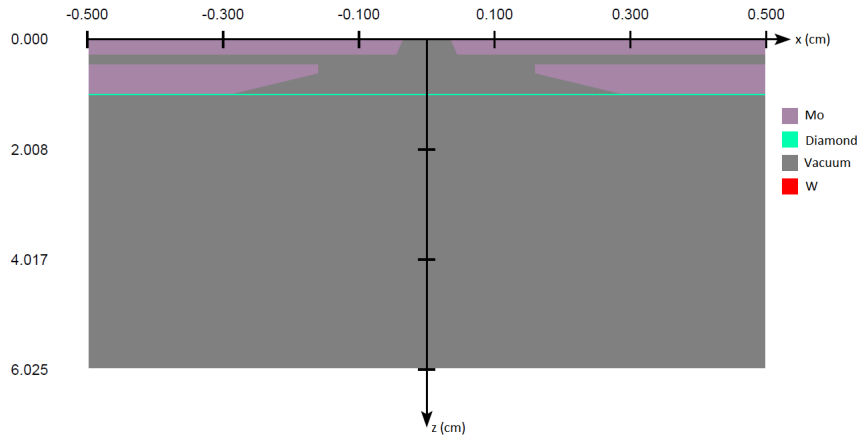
Design of the 160 kV FeinFocus transmission X-ray tube as specified in BEAMnrc
